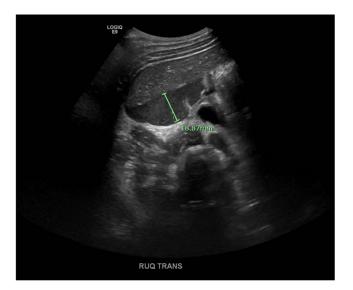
Right upper quadrant transabdominal ultrasound demonstrating complex free fluid in the hepatorenal space 1.9-cm wide suggesting hemoperitoneum.
